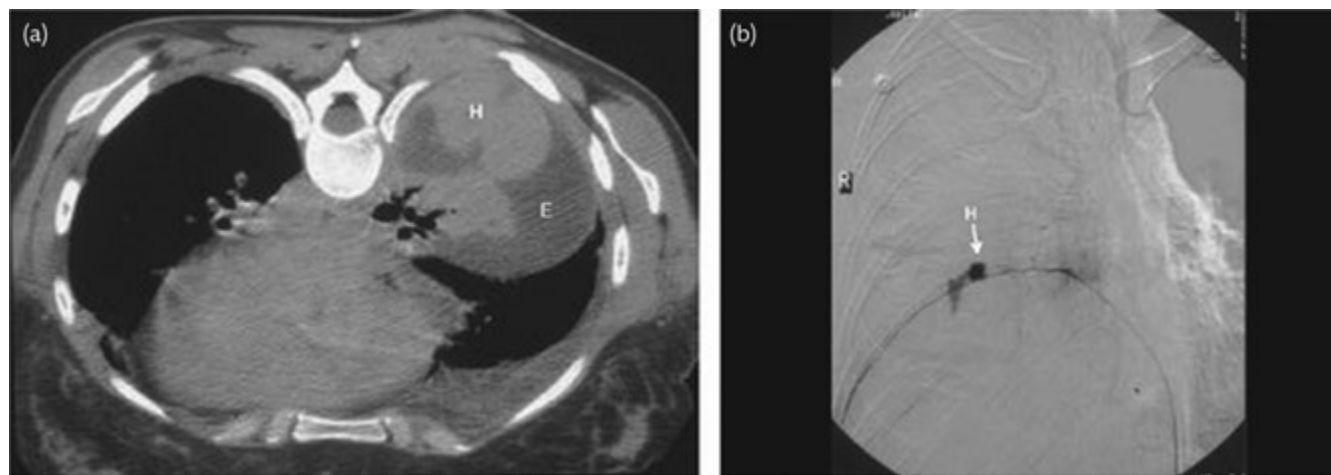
Haemothorax due to laceration of an intercostal artery during chest drain insertion. The CT (a) shows acute haemorrhage (H) into a pleural effusion that was already present (E). The angiogram (b) shows acute haemorrhage (H) from intercostal artery, which was halted by intercostal embolization.
